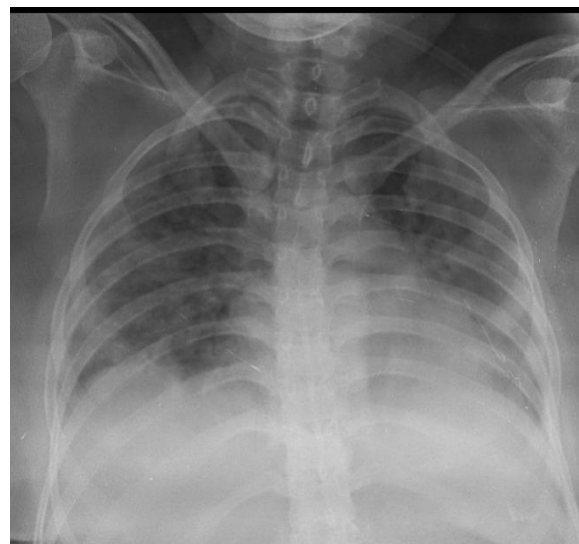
AP chest radiograph reveals multiple reticular opacities (thin arrow) and ground glass opacities (thick arrow) in central and peripheral distribution of both lungs.
